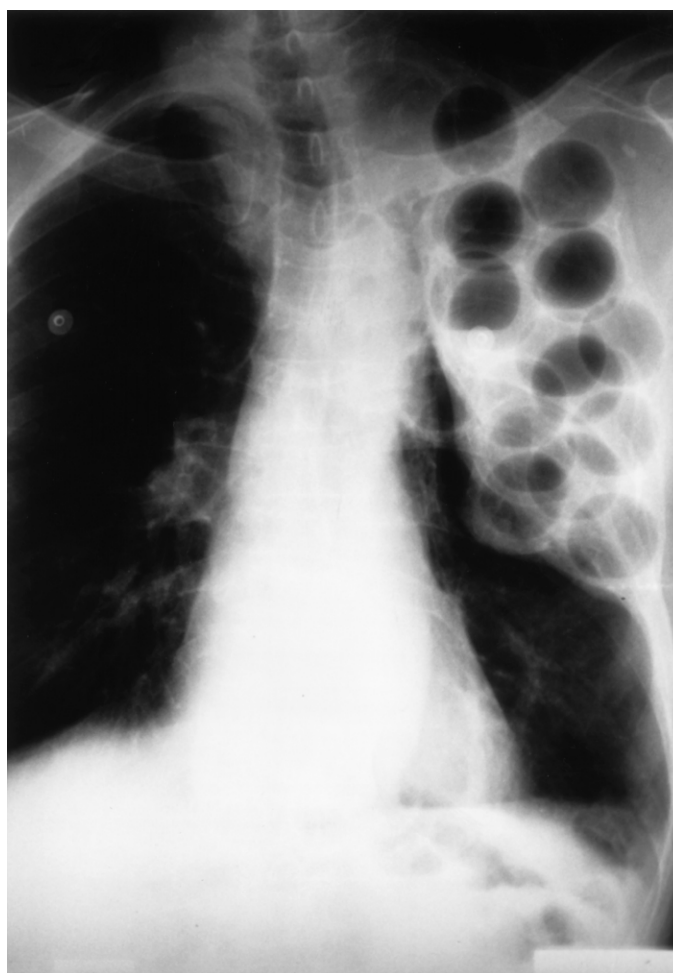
Posteroanterior chest radiograph of a 78-year-old man with a history of benign prostatic hypertrophy and diverticulosis. Plombage balls are present in the left upper lobe.
